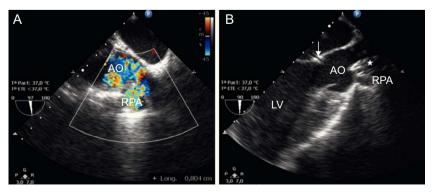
Transesophageal echocardiography. A: Measurement of the aortopulmonary window. B: Check for correct deployment of the device (asterisk) without any change in aortic valve function or outflow of the coronary conduct (arrow). AO, aorta; RPA, right pulmonary artery; LV, left ventricle.
